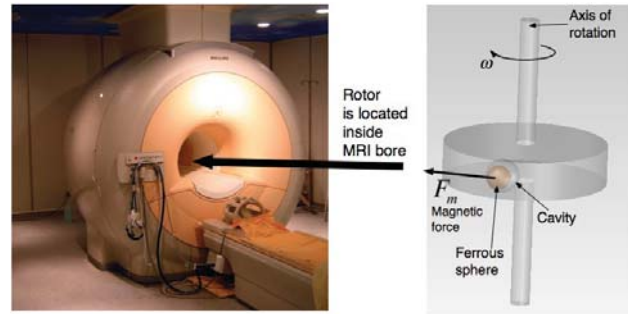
MRI-powered actuator. Interleaved imaging and propulsion pulse sequences are used to track rotor angle and generate magnetic-gradient-based forces enabling control of both motor position and torque.
